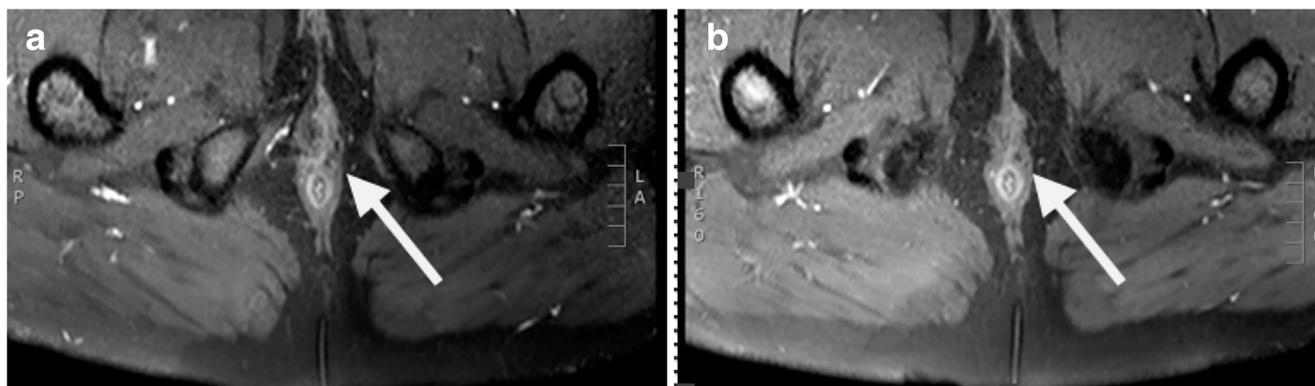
MRI before (a) and 4 months after (b) treatment. White arrow: fistula-in-ano site
